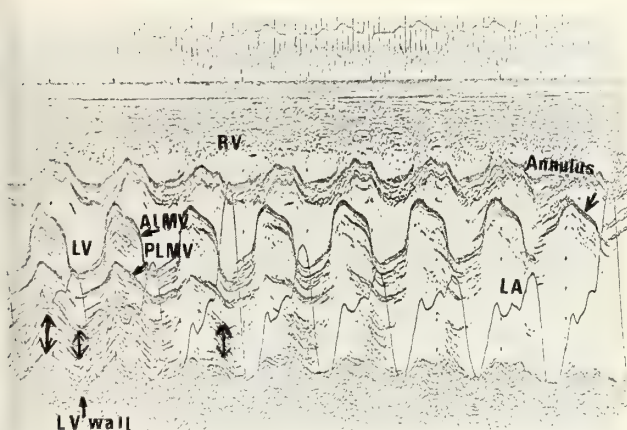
Echocardiogram showing a sweep from the body of the left ventricle into the left atrium at the level of the mitral annulus. A mass of mobile echoes below the paradoxically moving posterior mitral valve leaflet (PLMV) is demonstrated attached to the posterior left ventricular wall.
